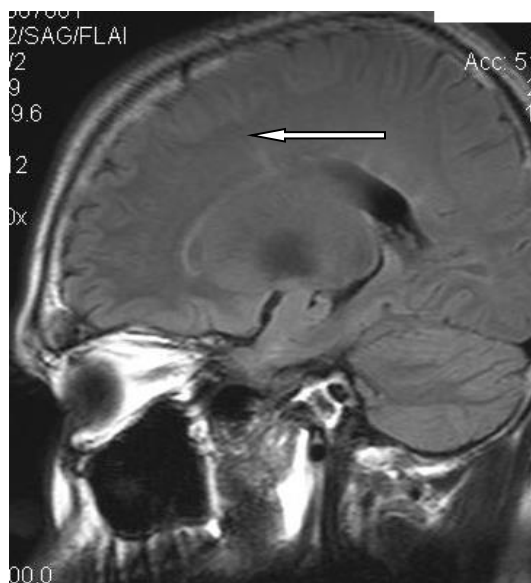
MRI image showing Dawson's fingers
